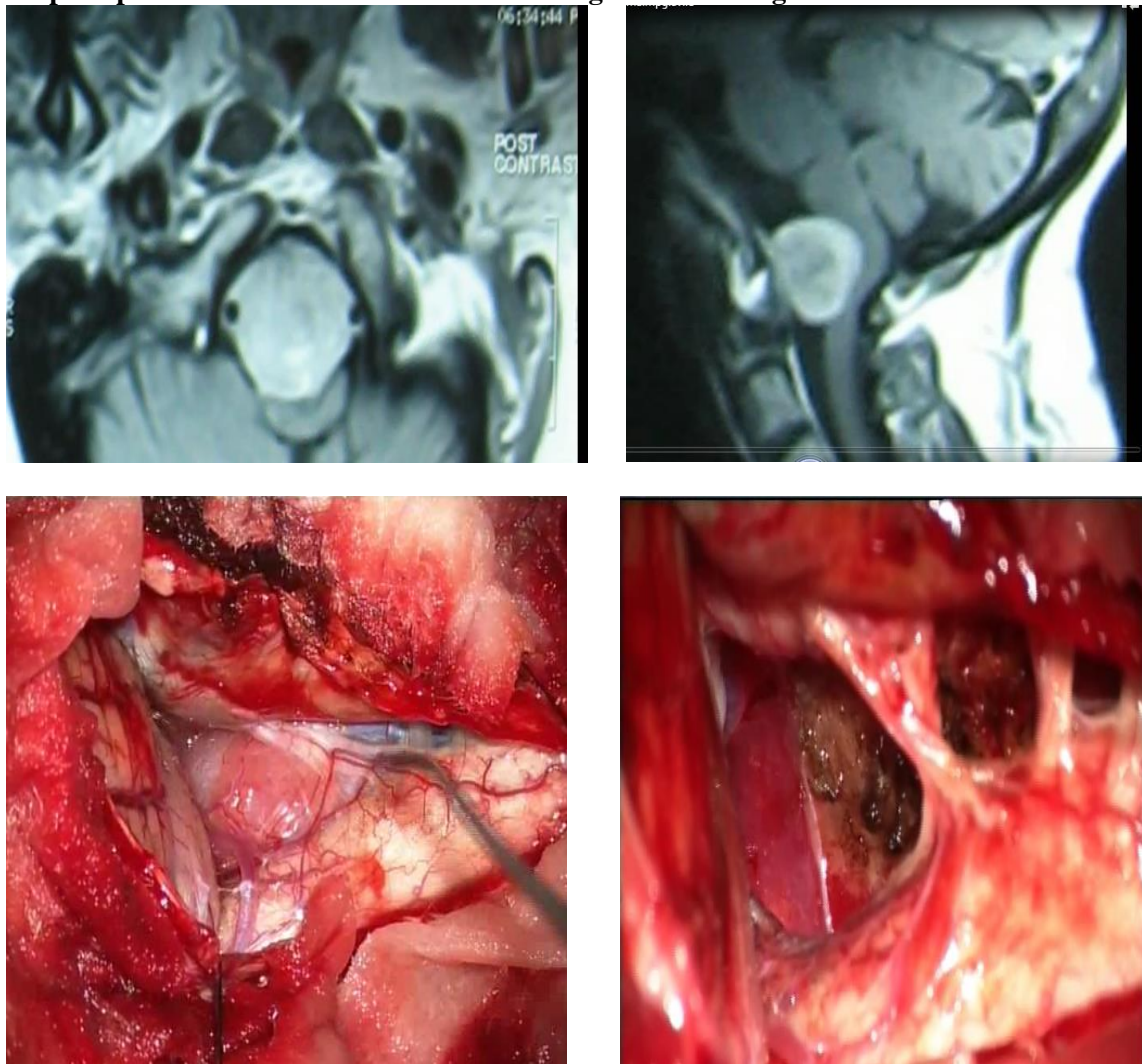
Figure IV post contrast axial and sagittal MRI of a case with sizable foramen magnum meningiomas
